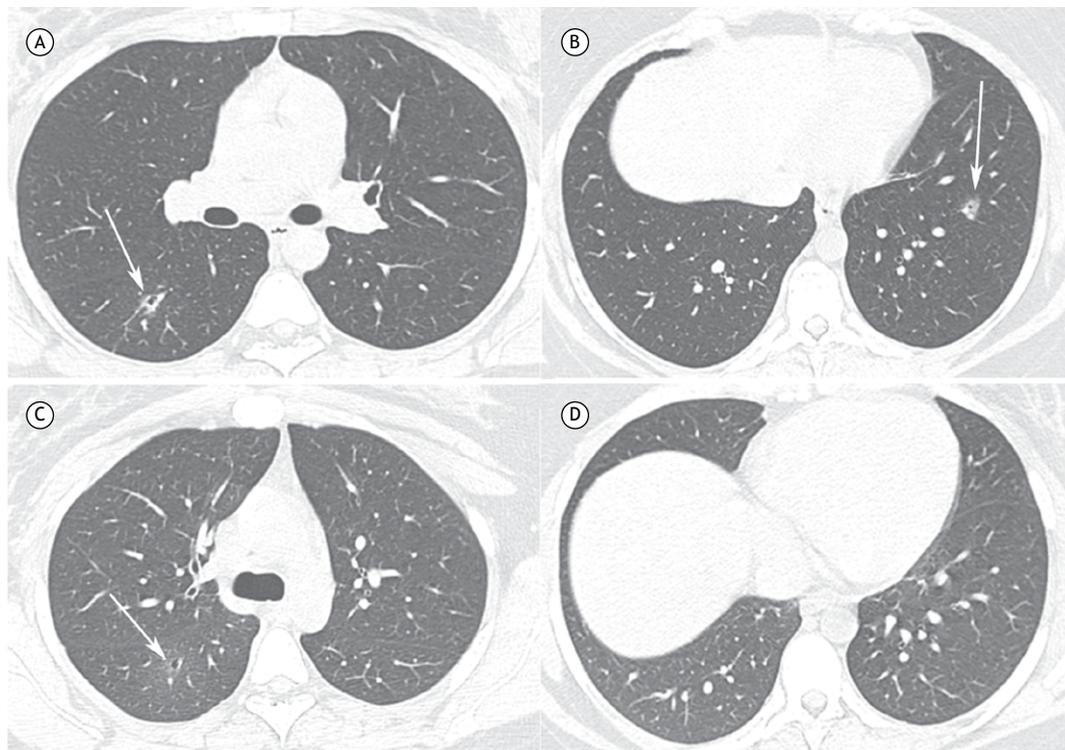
In A and B, chest CT scans acquired during the menstrual period, showing thickening of the nodule wall and the presence of another nodule with a similar appearance in the left lower lobe (arrows). The nodule in the left lower lobe was not evident in the image acquired between menses (in D). In C and D, chest CT scans acquired two weeks after menstruation, showing a small cavitary nodule located in the apical segment of the right lower lobe (arrow in C).
